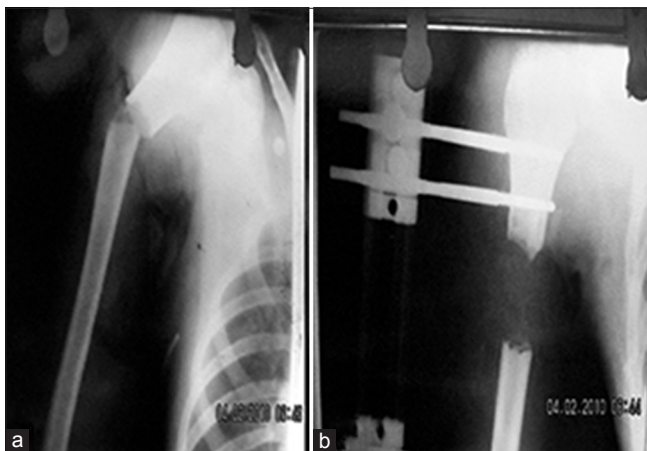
X-ray right arm with shoulder joint anteroposterior view showing (a) preoperative gap nonunion (b) immediate postoperative after removing dead piece of bone with final gap created
